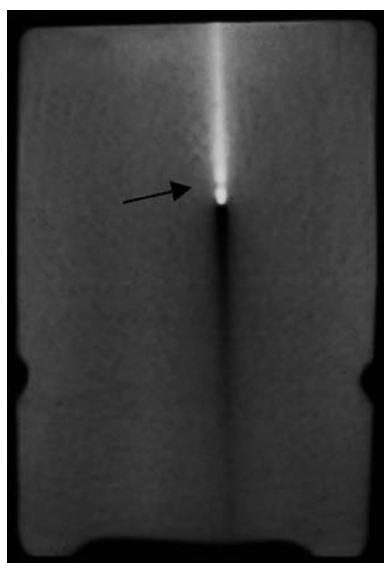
CT image of a side slotted needle aligned with the CT scanning plane and inside a water bottle. The needle tip can be identified with certainty when a distinctive feature, such as the notch (arrow) is visualized or when a shadowing artifact is seen extending from the tip. In this example, both of these features are present
